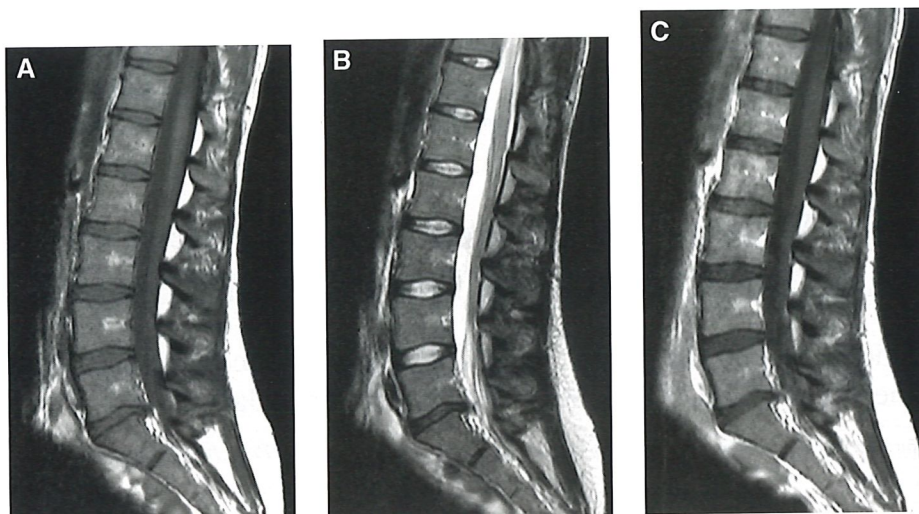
Normal marrow. (A) Sagittal T1- and (B) T2-weighted spin echo (SE) of the lumbar spine of a 23-year-old woman show homogeneous marrow appearance with more fatty marrow around the vertebral veins. (C) On the gadolinium-enhanced sagittal T1-weighted image, moderate signal intensity enhancement can be seen, merely by noting the artifactual decrease in signal intensity of the intervertebral disk. Enhancement percentage was 70%, as determined on quantitative dynamic MR imaging study (not shown).
